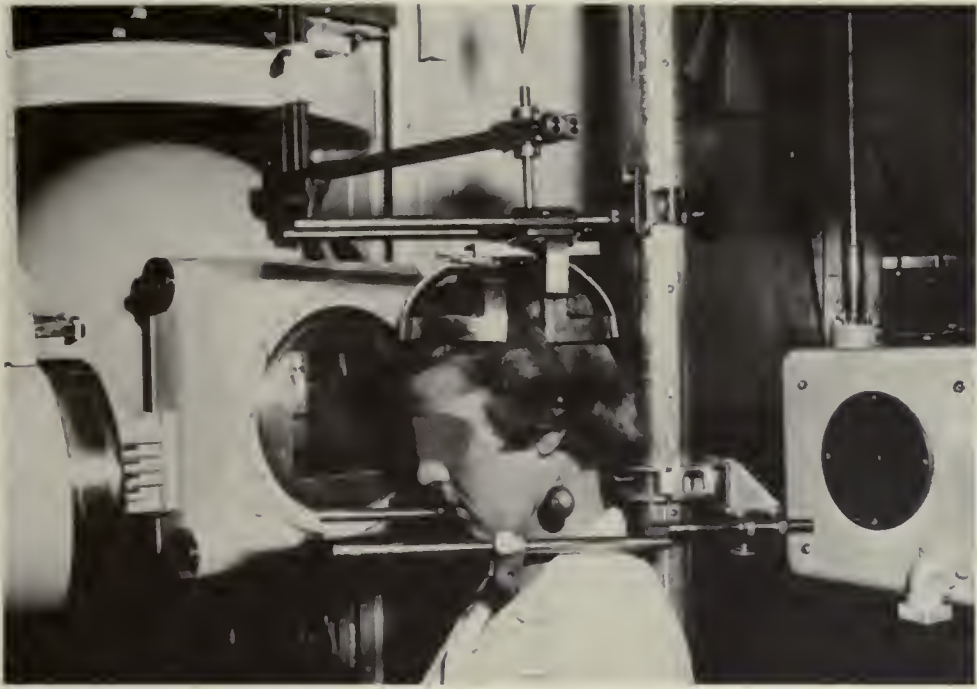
Special head holder and chin holder with locking mechanism attached above to the cobalt therapy machine. The image intensifier is at the right, and the diagnostic 140-kv X-ray equipment is at the left.
